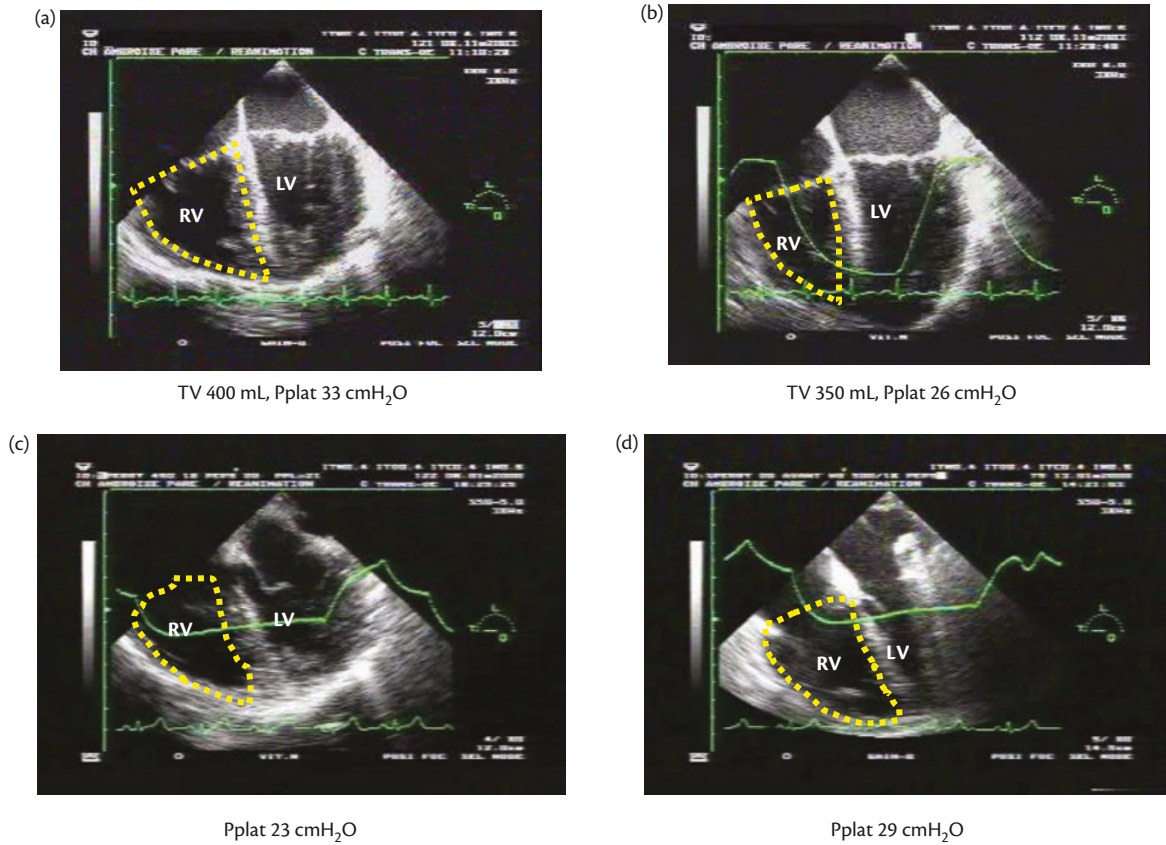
Long-axis view of the left ventricle by transoesophageal echocardiography (TEE) in patients mechanically-ventilated for severe ARDS. (a) Here, TEE demonstrates acute cor pulmonale (note the significant RV dilatation). After reduction of tidal volume and plateau pressure, RV size was normalized (b). In patient 2, note the deterioration of RV function related to the decrease in compliance and increase in plateau pressure from 23 (c) to 29 cmH₂O (d). TV, tidal volume; Pplat, plateau pressure; RV, right ventricle; LV, left ventricle.
